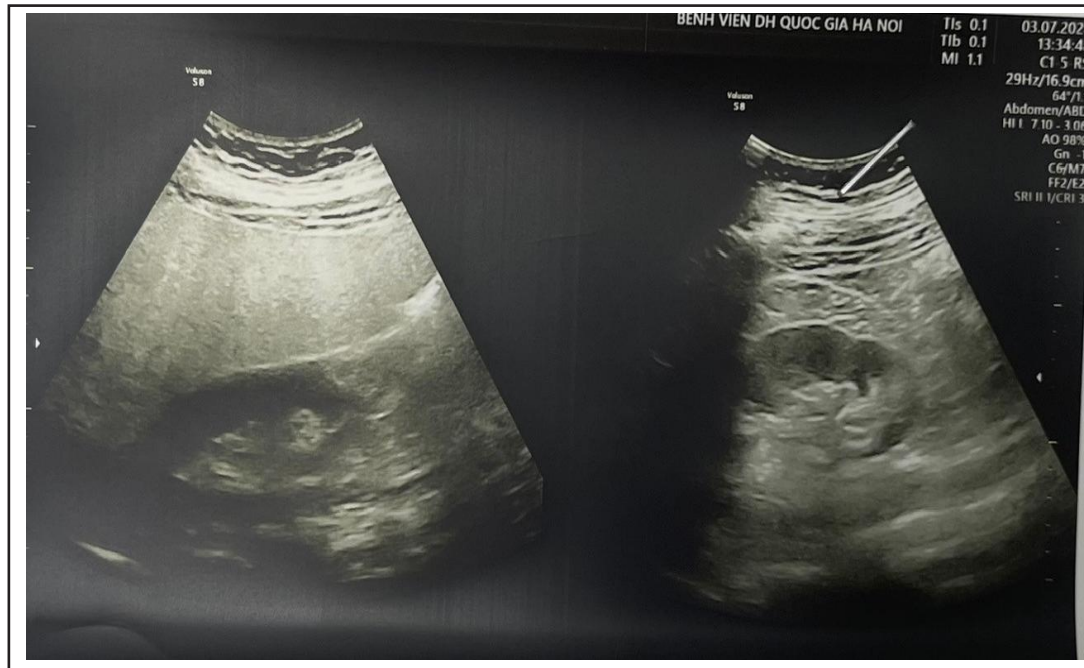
Result of Abdominal Ultrasound.
